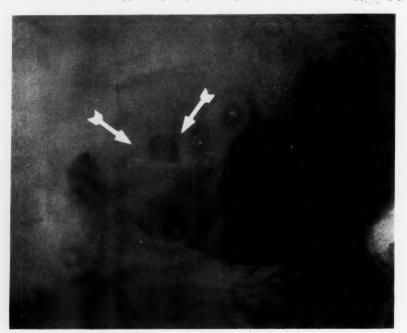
Case 2: Roentgenogram after ten weeks of jejunal alimentation. The ulcer pocket is one-third its former size.
